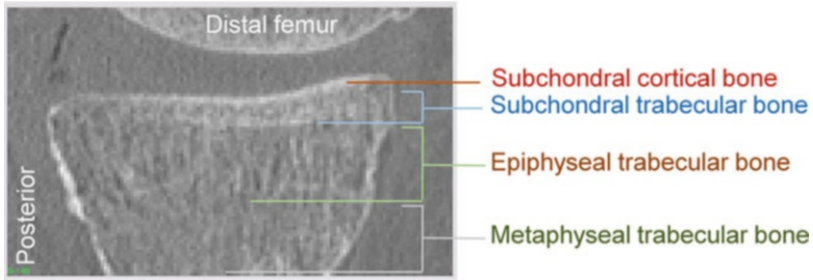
Sagittal computed tomography (CT) image of the proximal tibia and pertinent bony components, including subchondral cortical, subchondral trabecular, epiphyseal trabecular, and metaphyseal trabecular bone. Neither cartilage nor the meniscus is observed in this image because neither tissue can absorb radiation
